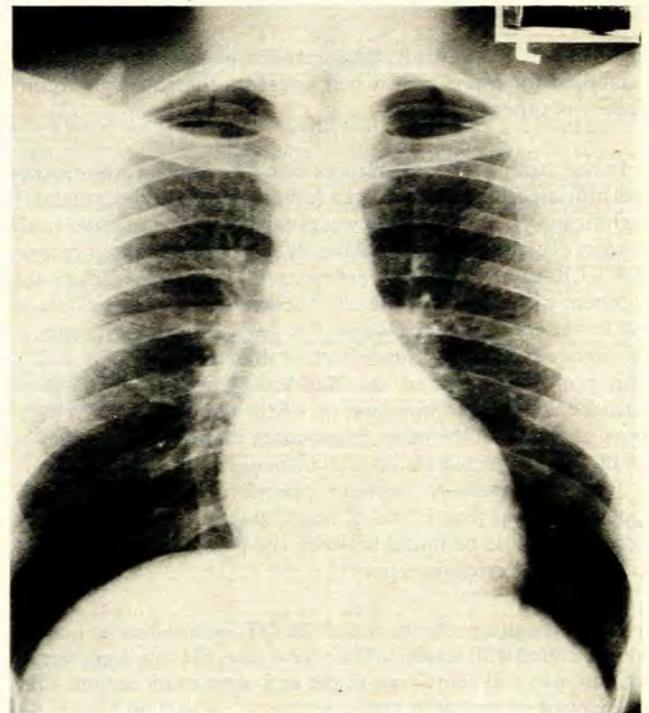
Postero-anterior chest radiograph of patient 7. The cardiothoracic ratio is 0.50 but there is a prominent shelf-like appearance to the left heart border which gives the left ventricle a 'bulky' appearance, and is compatible with LVH.
